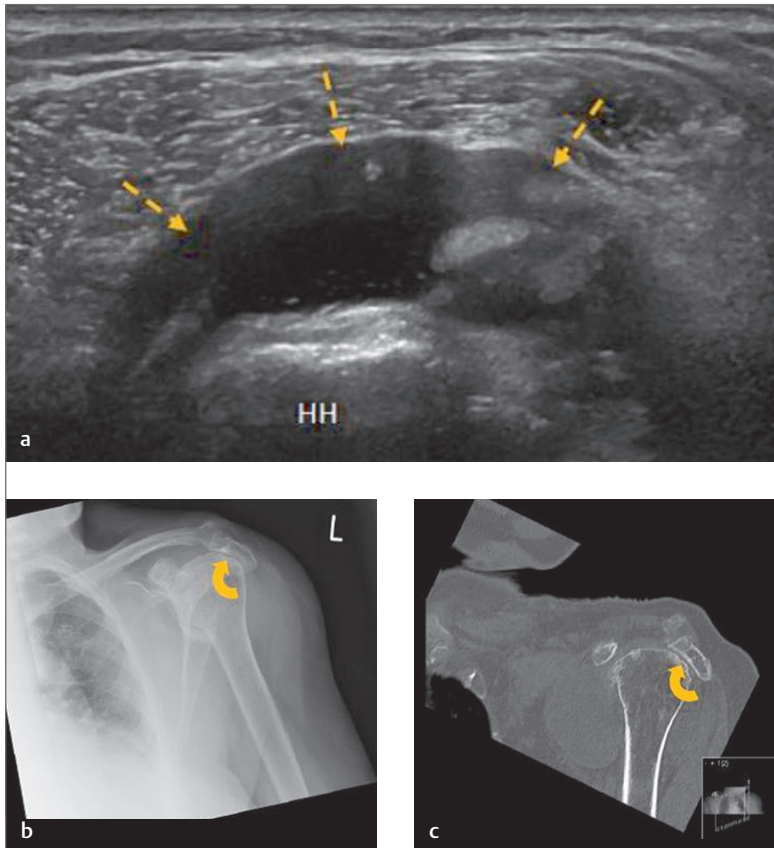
(a) Transverse image of the tendon of supraspinatus. The tendon cannot be seen over the humeral head in keeping with a complete rupture. In addition, there was a large subacromial bursal effusion with associated bursal thickening (dashed arrows). (b) X-ray of the same shoulder demonstrates a marked reduction in the acromiohumeral space in keeping with a complete rupture of the supraspinatus tendon (curved arrow). (c) CT of the same shoulder demonstrating an advanced osteoarthritis involving the glenohumeral joint with marked loss of joint space, large osteophyte formation, subchondral sclerosis and cyst formation, and a decreased acromiohumeral space (curved arrow). HH, humeral head.
